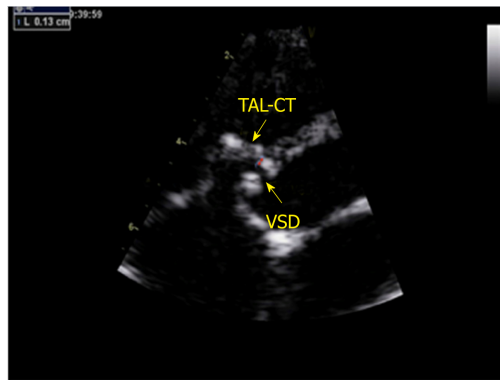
Non-standard aortic short-axis view. The red arrow shows the distance (1.3 mm) from the attachment point of the tricuspid anterior leaflet chordae tendineae to the inferior edge of the right ventricular side. TAL-CT: Tricuspid anterior leaflet chordae tendineae; VSD: Ventricular septal defects.
